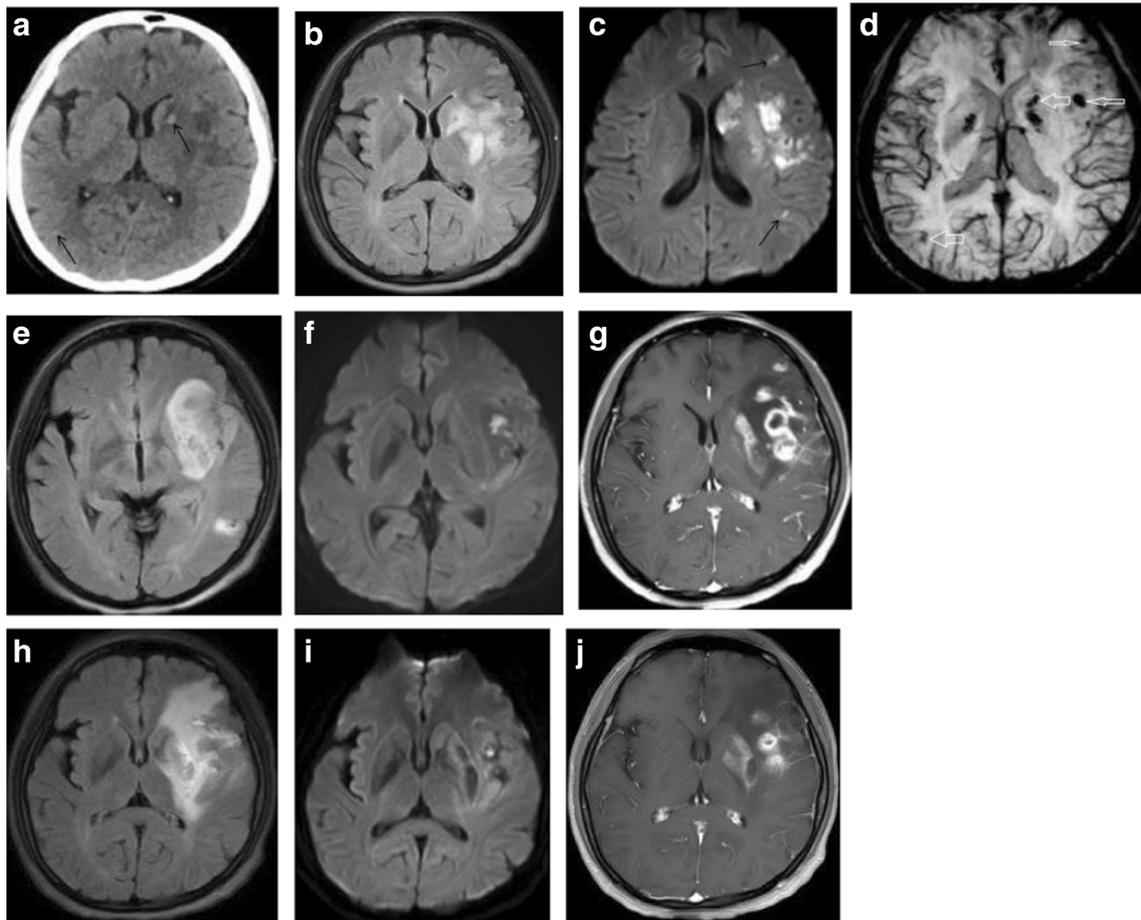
Patient 1. a Brain CT performed 4 days later after onset of slurred speech and right lower extremity weakness shows irregular patchy hypodensities in the left temporal lobe and basal ganglia, and multiple small hemorrhages in the above-mentioned areas and gray-white matter junctions of the right parietal lobe (arrows). b–d MRI performed on the 5th day. The lesions in the left temporal lobe and basal ganglia are hyperintense on FLAIR (b) and DWI (c), and DWI shows many other punctate lesions (arrows). ADC image shows the diffusion is restricted (not included). d SWI shows multiple hypointensities disseminated in the above-mentioned areas (arrows; part of them not included in the picture) indicating hemorrhagic transformation of the infarction and hemorrhages of different time. The patient was treated with antibiotic and thrombolytic
